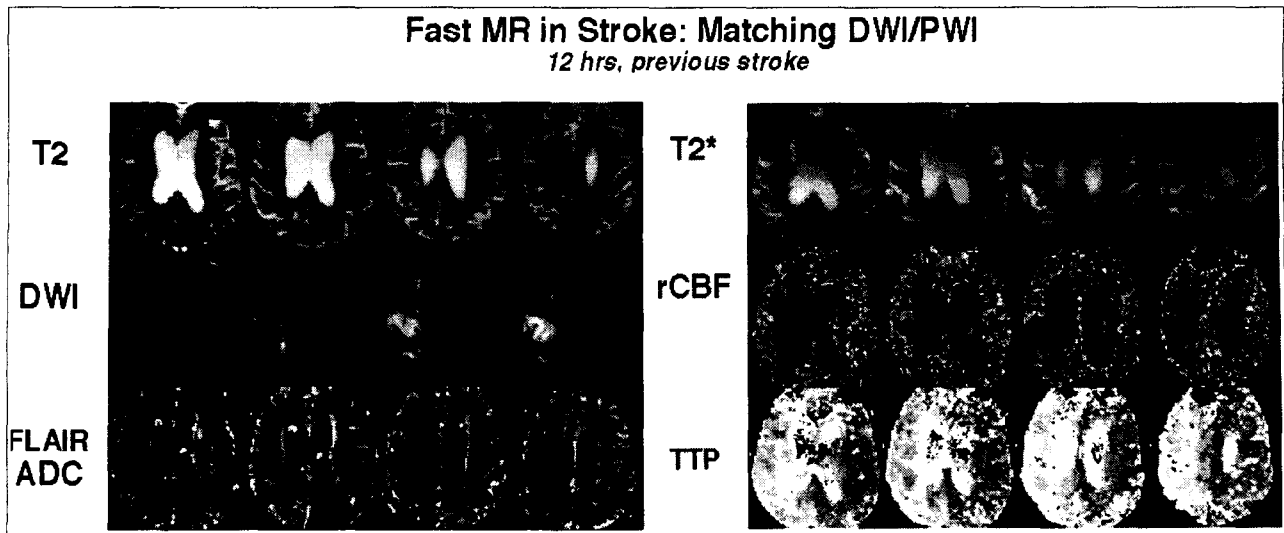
Integrated DWI and PWI exam. At early timepoints, T2 maps do not show presence or extent of the ischemic lesions, easily seen on DWI or on ADC maps. FLAIR ADC maps are often used to suppress bright CSF from the ADC maps, which obscures the lower-than-normal lesions. Correlating with this, the PWI maps show a lower than normal rCBF (determined from the rCBV and transit maps). Note however, that the entire hemisphere shows a longer transit index, indicative of a larger perfusion or hemodynamic difficult than the focal lesion seen on DWI.
